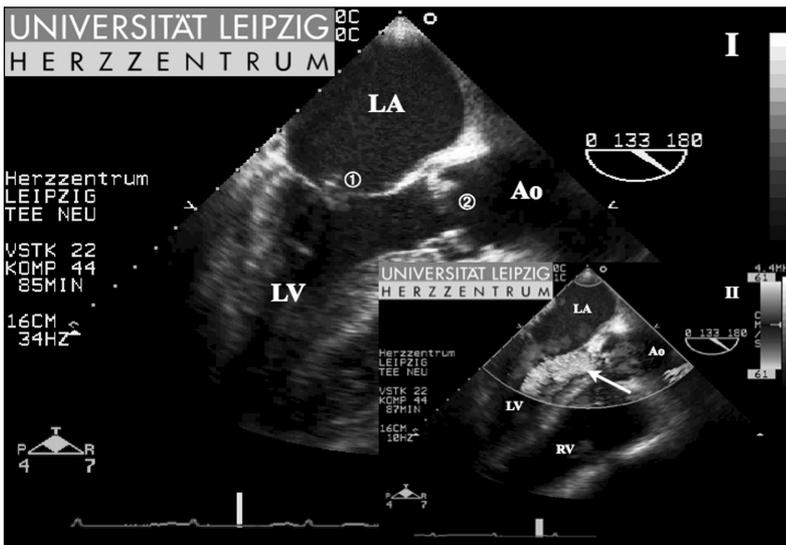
(I) Intraoperative midesophageal long axis view of the aortic valve at a multiplane angle of 133 degrees. Vegetations on ventricular and atrial side of the mitral valve are demonstrated (⊙). Additionally, vegetations on the aortic valve are shown (⊚). (II) In the same view the color Doppler demonstrates a concomitant severe regurgitation in the left ventricular outflow tract (←). LA = left atrium; LV = left ventricle; RV = right ventricle; Ao = ascending
